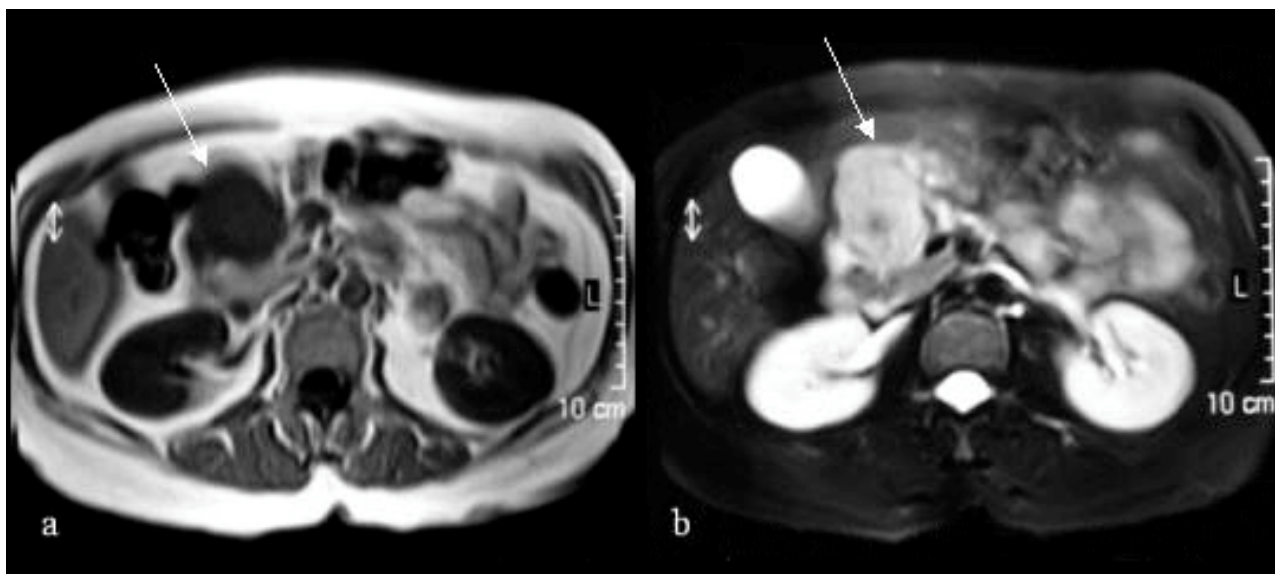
Abdominal magnetic resonance imaging shows a well-capsulated, isodense, solid mass (a. arrows, T1-weighted) and heterogeneous signal characteristics, that is, a central hypodense area within the mass (b. T2-weighted).
